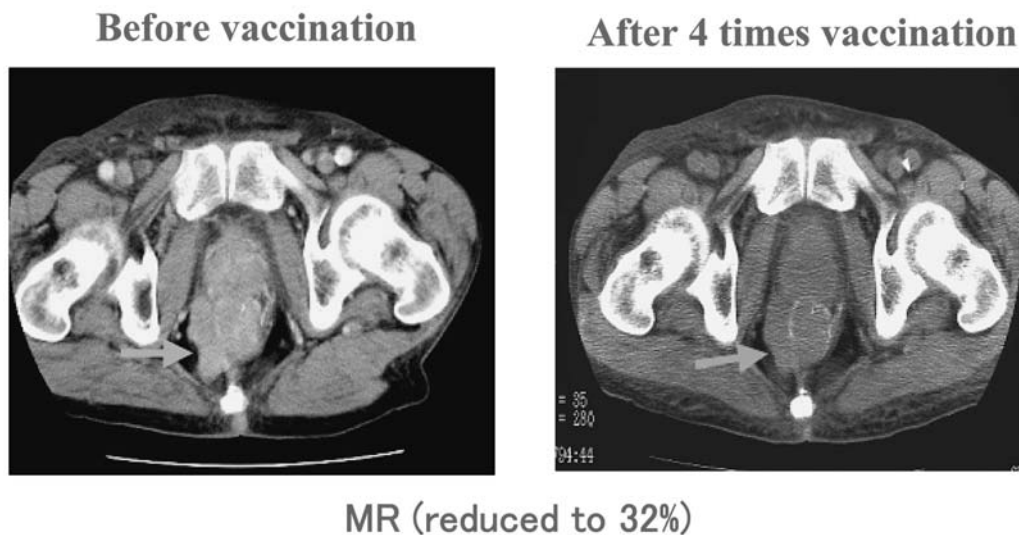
A representative CT view of a colon cancer patient subcutaneously administered survivin 2B cancer peptide vaccine, showing 32 % regression of colon cancer (arrows). Left and right CT views show before and after 4 vaccinations, respectively.
